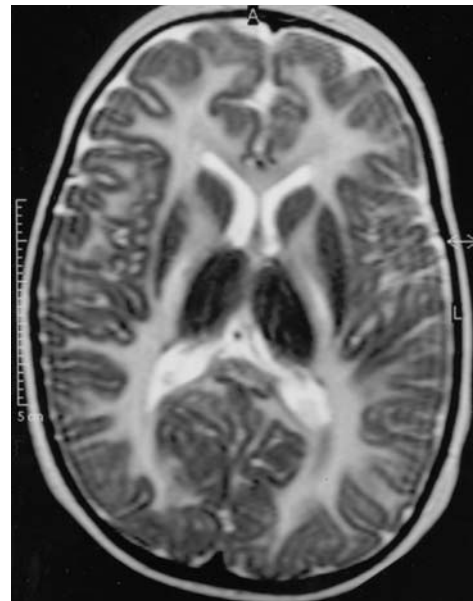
Axial T2 MRI (mod.) of a 7-month-old girl with penular nystagmus and hypotonia: “lack” of myelination, etiology unknown
